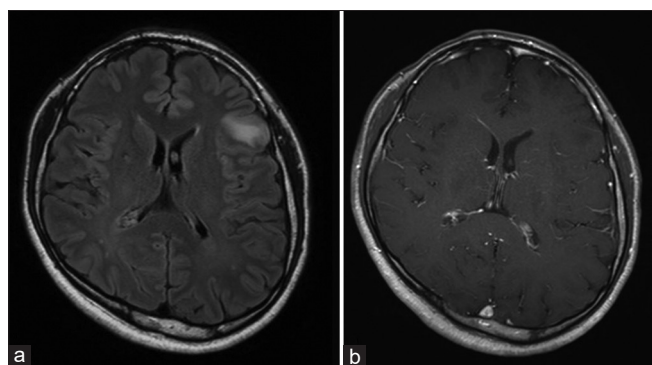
Magnetic resonance imaging, performed during the patient's previous visit, showed (a) a T2 fluid-attenuated inversion recovery high homogeneous lesion with a 25 mm diameter in the left frontal lobe (pars triangularis), (b) The lesion was non-enhanced, suggesting a low-grade glioma.
